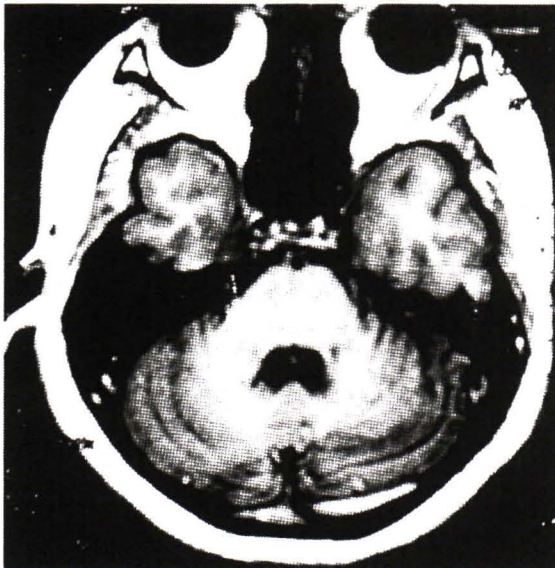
MRI of the brain at the onset of the disease demonstrates mild cerebellar atrophy.
